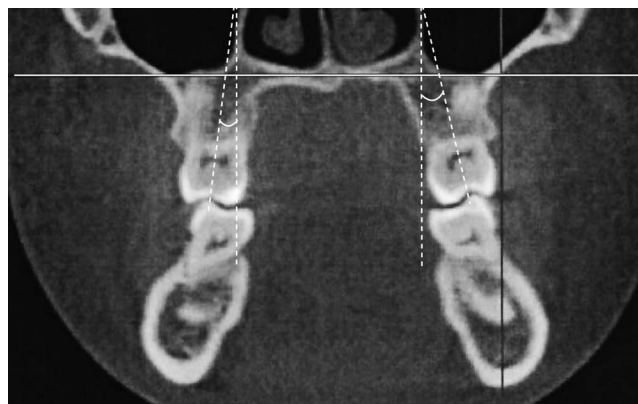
CBCT showing coronal section of maxillary first molars.
